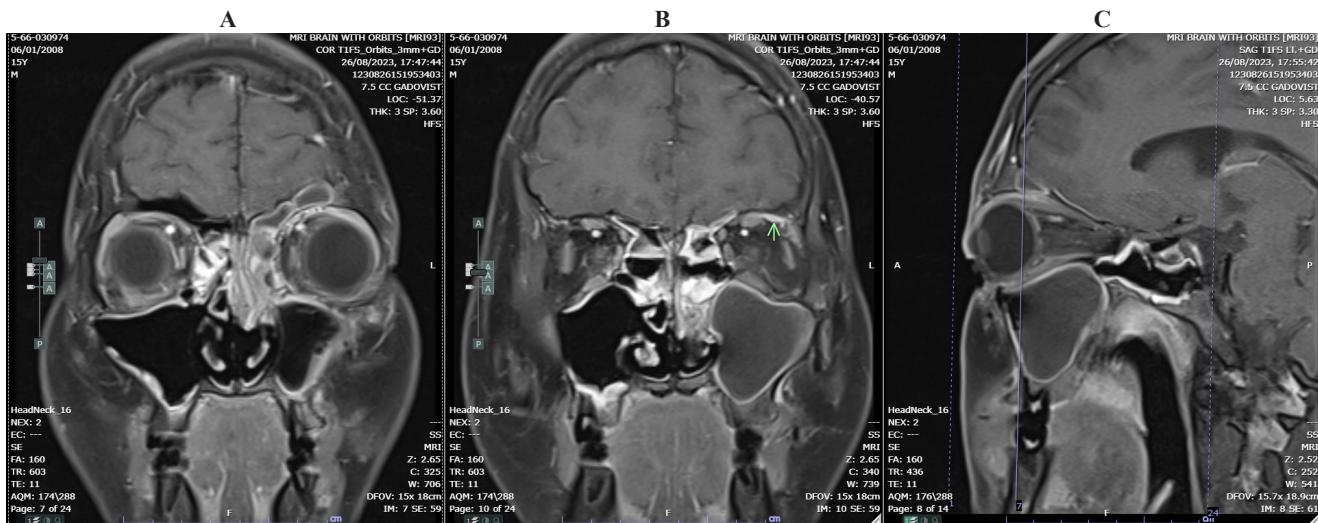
Magnetic resonance imaging (T1 with contrast). (A, B) Coronal views demonstrated left-sided fronto-ethmoidal sinusitis with abnormal contrast enhancing dura along the inferior frontal region and superior extraconal space of the left orbit (arrow). (C) A sagittal view revealed left-sided frontal sinus mucosal thickening with enhancing inflammation.
